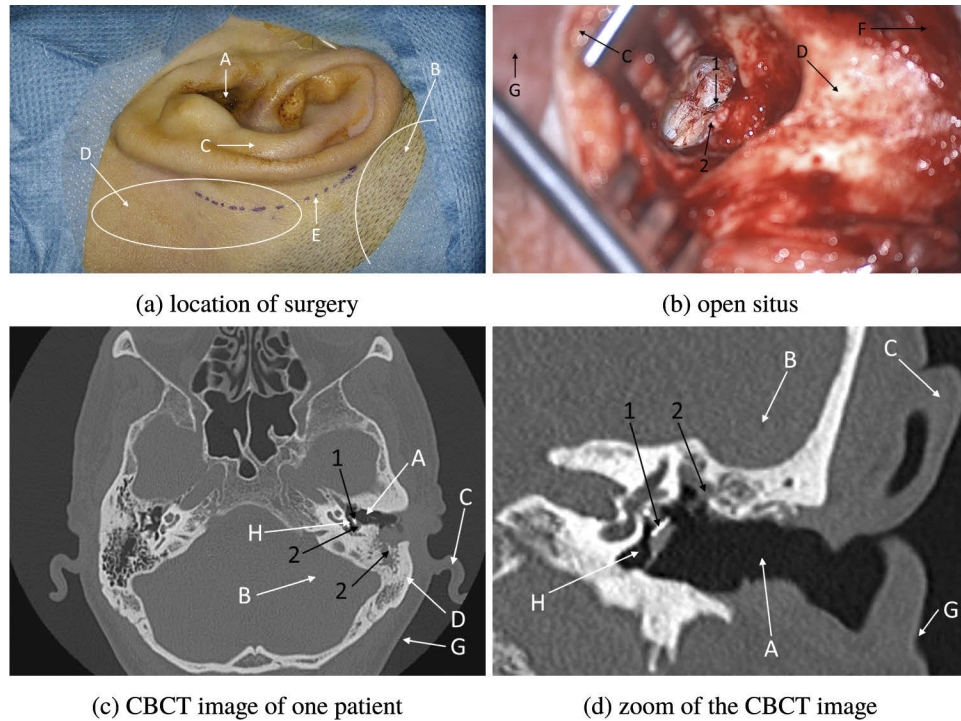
These images show the location (a) and anatomy (b) of the interventions. An open situs, where all relevant tissue structures are visible, is shown in (b). The position of this situs is shown in the left image marked with the dashed incision line (E). The corresponding CBCT images (c) and (d) show the location of the cholesteatoma in the left ear. The labels describe: A - external ear canal, B - brain, C - catilage, D - mastoid bone, E - incision line, F - musculus temporalis, G - skin, H - middle ear, 1 - tympanic membrane with titanium prosthesis, 2 - cholesteatoma with bone arrosion.
